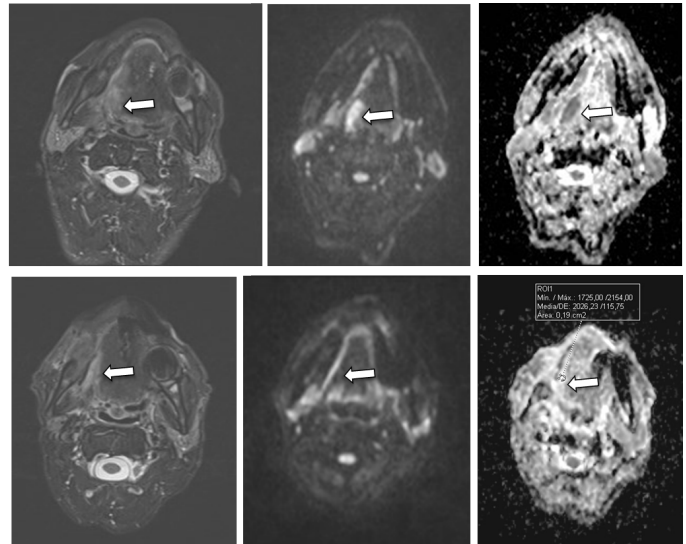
Oropharyngeal carcinoma. A. A focal area of abnormal signal intensity in the base of the tongue and right tonsil (arrow) in axial T2-WI is seen. B. It is hyperintense on DWI (b value  $1000 \text{ sec}/\text{mm}^2$ ) (arrow). C. On ADC map it shows low signal intensity (values not shown) (arrow), compatible with restricted diffusion. In this case, the restricted-diffusion lesion most likely corresponds to malignancy.
